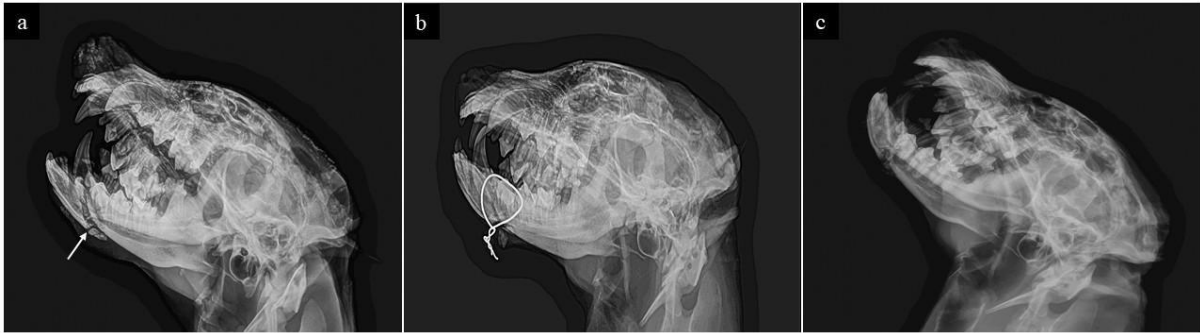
Lateral radiographs of the skull showing the left mandibular fracture indicated by a white arrow (a), fixation using 16 SWG wire placed perpendicular to the fracture line (b), and restoration of occlusion at 12 weeks (c).
